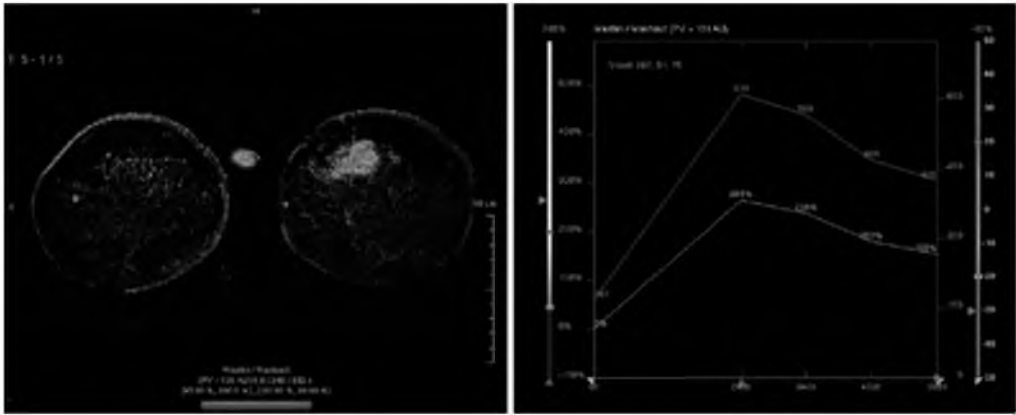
Subtracted MRI image. In the left breast a large IDC is present with strong enhancement and typical early wash-out of contrast (curves respectively present percentages (lower curve) and arbitrary units (upper curve)), indicative of the malignant nature of the lesion.
